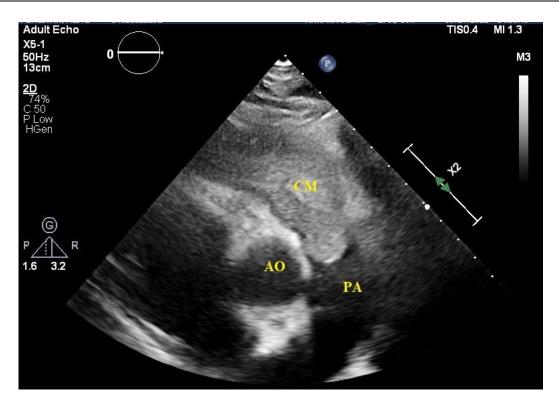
Transthoracic echocardiography revealing right ventricular mass protruding through the pulmonic valve during systole. Parasternal short axis view. CM: Cardiac myxoma, AO: Aortic valve, PA: Pulmonary artery.
